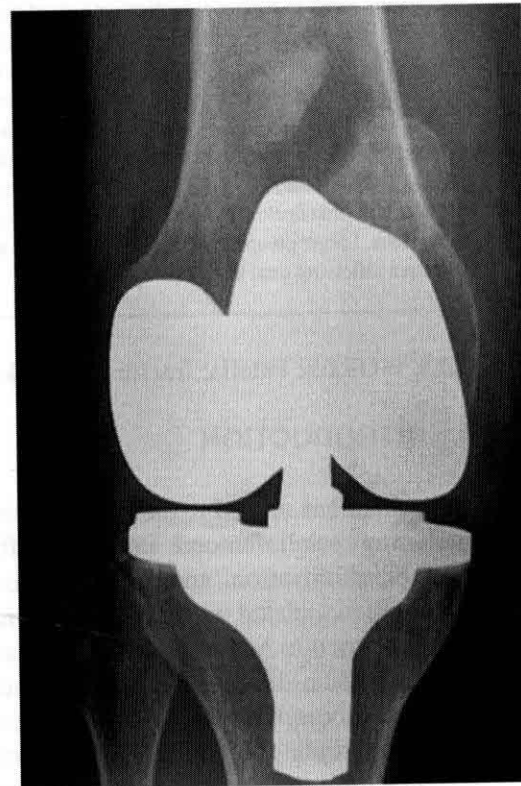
AP knee radiograph demonstrating patella fracture after total knee arthroplasty.
